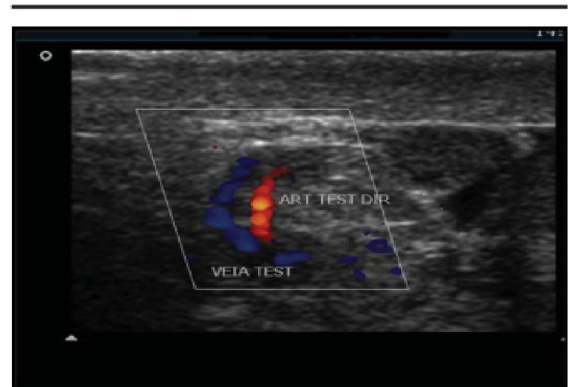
Doppler ultrasonography showing the testicular artery in red and the testicular vein in blue
